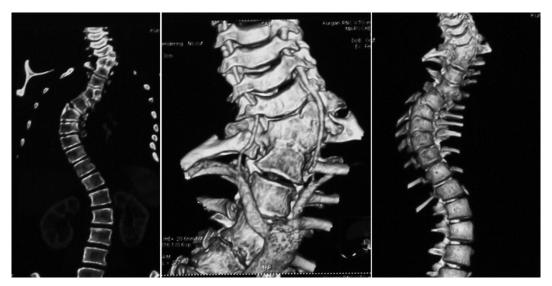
CT image of the defect in the sagittal slice and by multispiral 3D reconstruction
